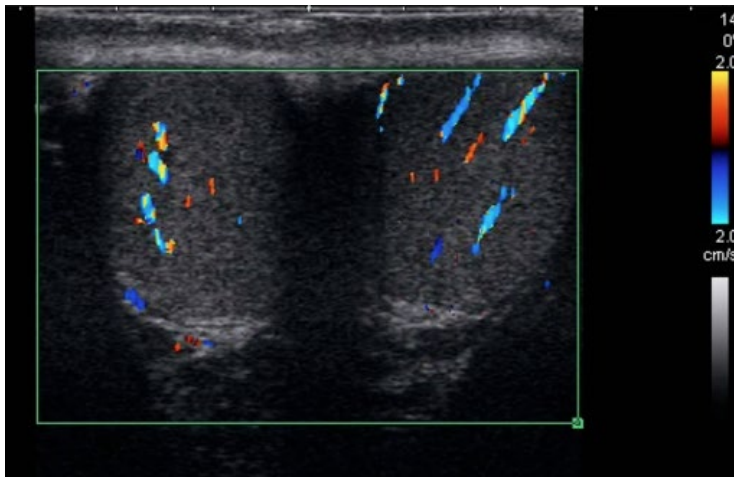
Simultaneous testicle visualisation ('buddy view') with colour Doppler allows comparison of echo texture, size and flow. Both testes in this case have a normal homogeneous echotexture and similar flow.
